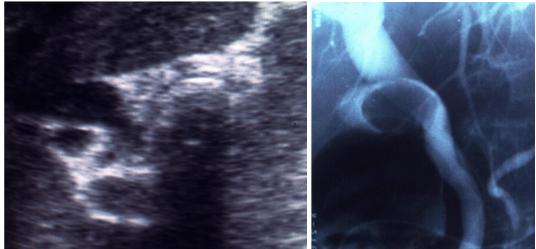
a, b Mirizzi's syndrome sonographically and by ERCP (two different cases); FS right (a, b), and ERCP (b)
